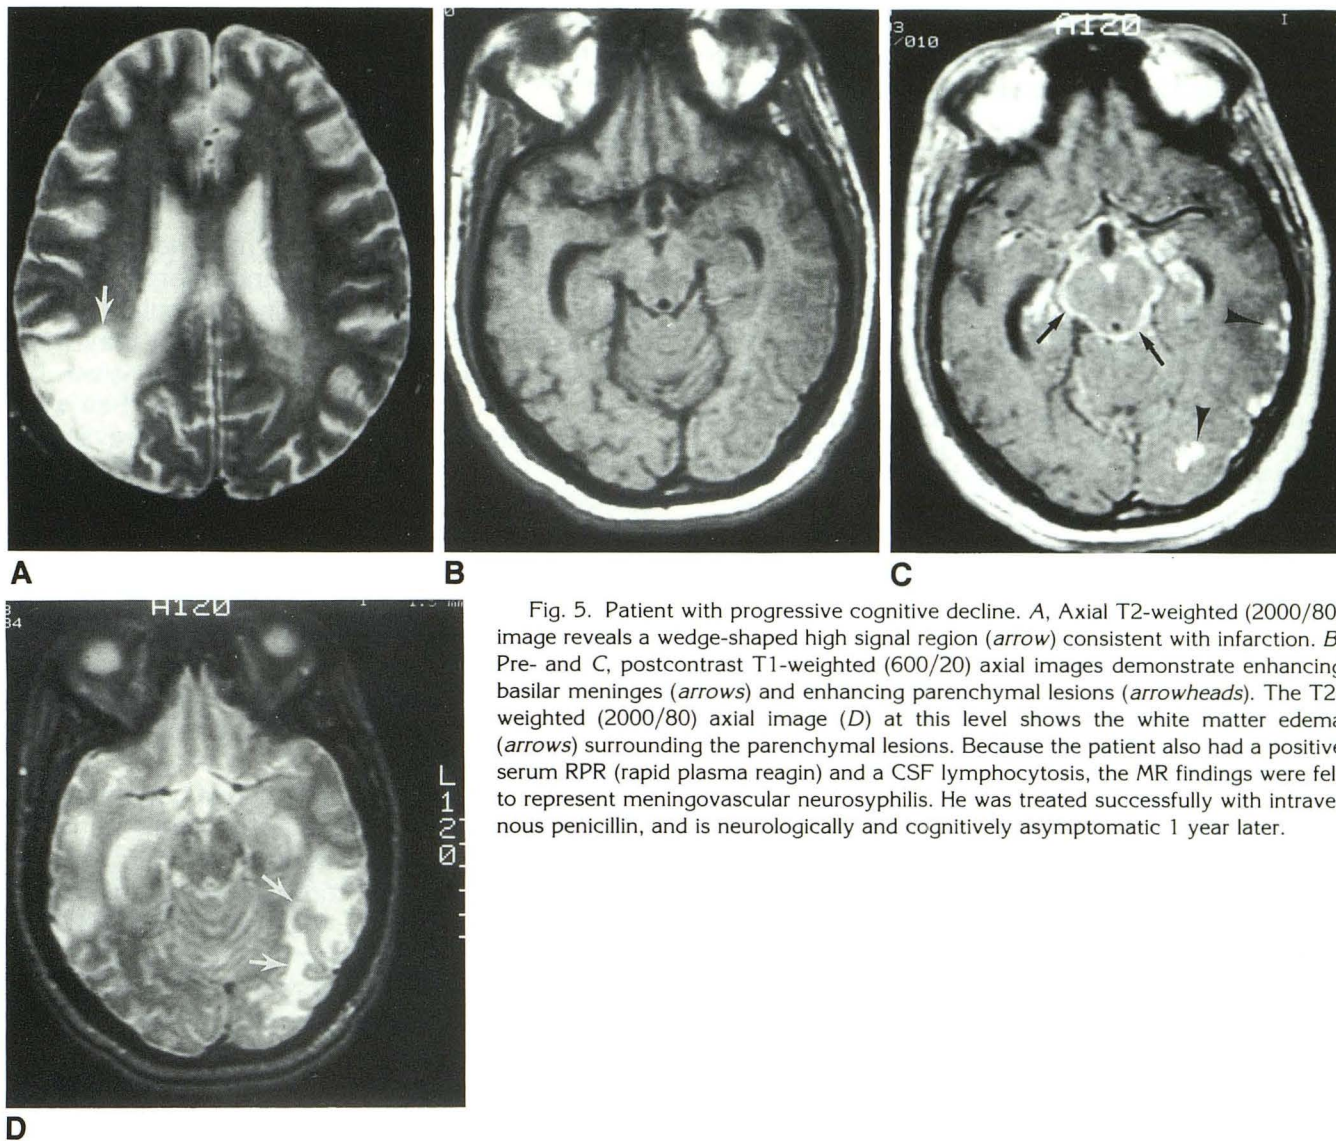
Patient with progressive cognitive decline. A, Axial T2-weighted (2000/80) image reveals a wedge-shaped high signal region (arrow) consistent with infarction. B, Pre- and C, postcontrast T1-weighted (600/20) axial images demonstrate enhancing basilar meninges (arrows) and enhancing parenchymal lesions (arrowheads). The T2-weighted (2000/80) axial image (D) at this level shows the white matter edema (arrows) surrounding the parenchymal lesions. Because the patient also had a positive serum RPR (rapid plasma reagin) and a CSF lymphocytosis, the MR findings were felt to represent meningovascular neurosyphilis. He was treated successfully with intravenous penicillin, and is neurologically and cognitively asymptomatic 1 year later.
